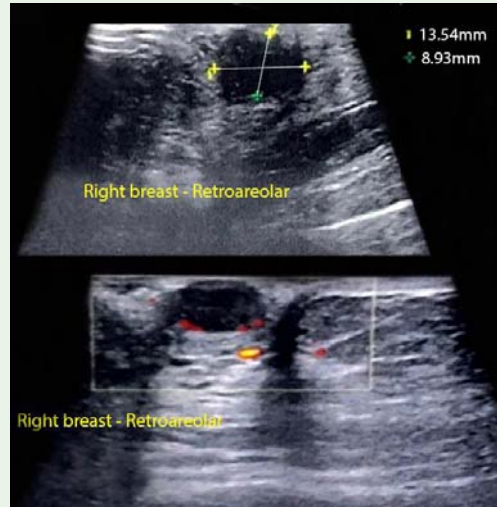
Ultrasonography: an irregular nodule with circumscribed margins and posterior acoustic shadow on the right breast nipple.
